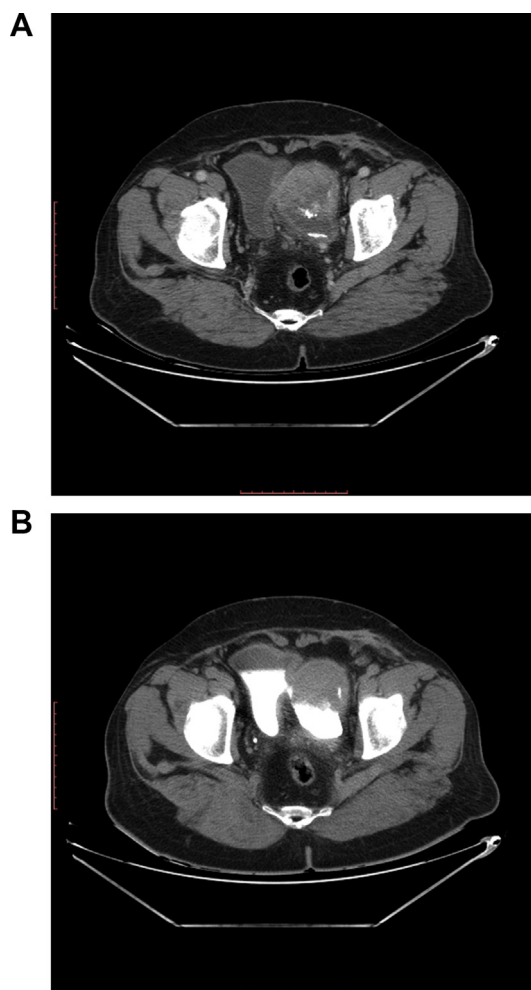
A: multiphase computed tomography scan shows a large bladder diverticulum with a tumor (8.2*5) with multiple stones. B: CT urogram shows small diverticular communication within the bladder lumen.
